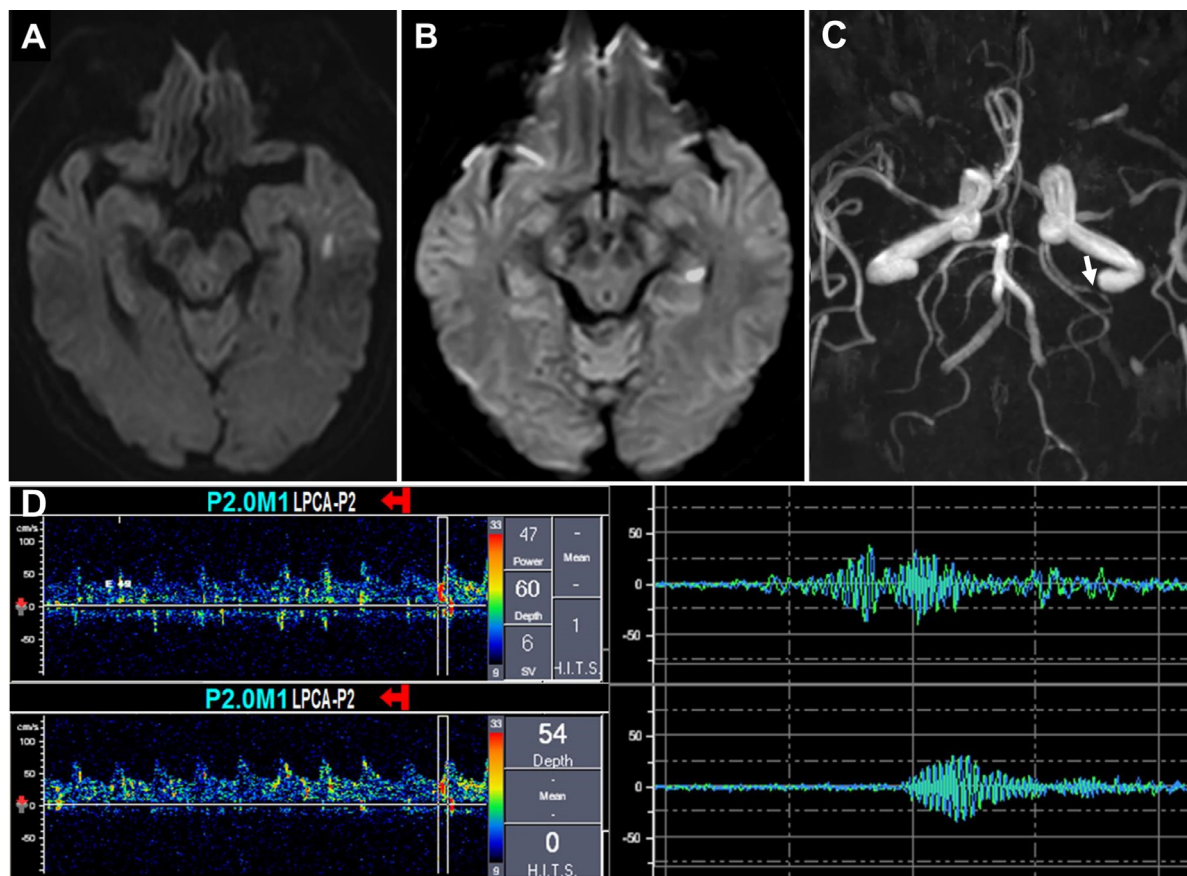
(A) Diffusion-weighted imaging (DWI) before 1 year showed left temporal lobe infarction. (B) DWI after this admission showed left hippocampal punctate hyperintensity. (C) Magnetic resonance angiography revealed the severe stenosis of left accessory PCA (white arrow). (D) Transcranial Doppler emboli monitoring detected the microemboli signals on left accessory PCA.
